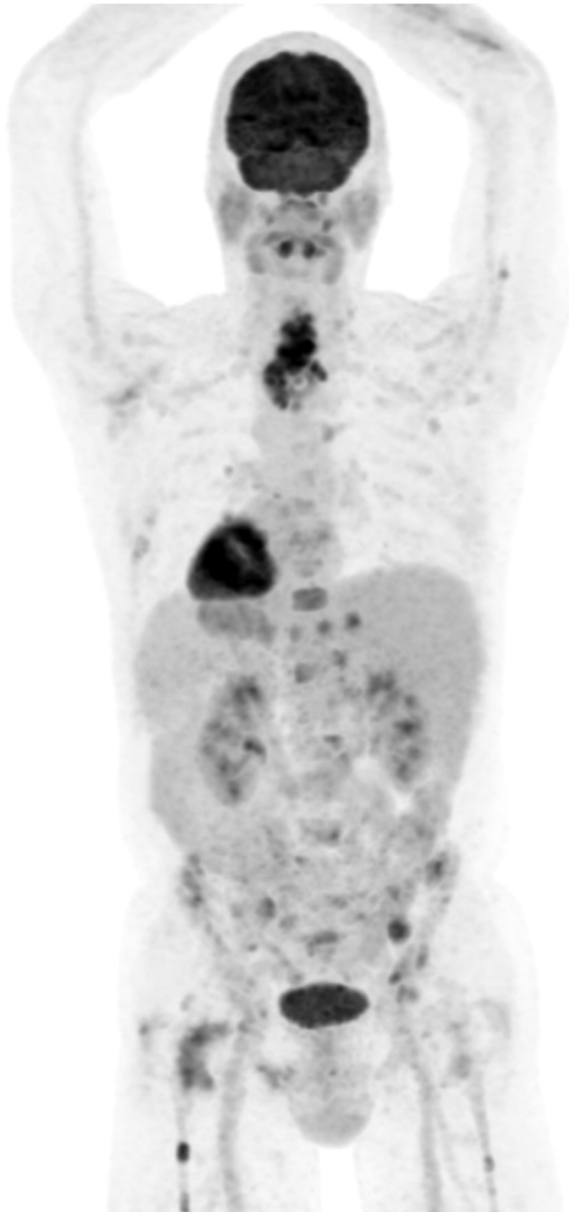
Maximum intensity projection (MIP) reconstruction of a fluorodeoxyglucose positron emission tomography/computed tomography scan showing a large tumoral process at the level of the larynx and proximal trachea, multiple suspicious lymph nodes in the neck and the mediastinum, as well as diffuse metastases in bone and bone marrow, liver, lung, and right adrenal gland.
